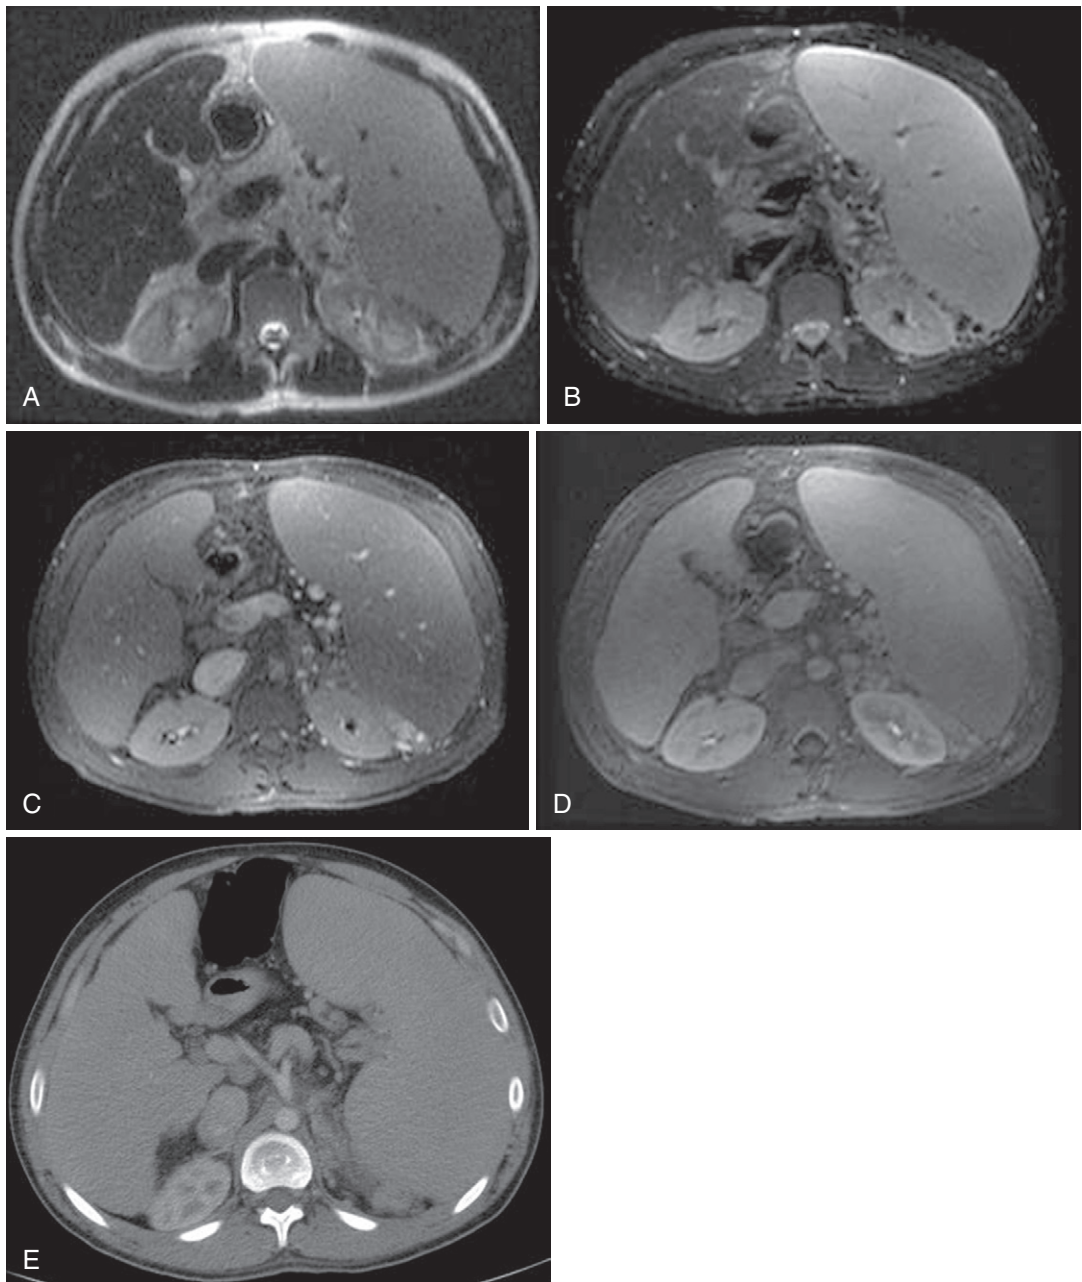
Cystic fibrosis. T2-weighted (A), fat-suppressed T2-weighted (B), venous phase (C), and delayed phase (D) postcontrast fat-suppressed T1-weighted gradient recalled-echo images and unenhanced CT image (E) demonstrate complete fatty replacement of the pancreas in a patient with cystic fibrosis.
